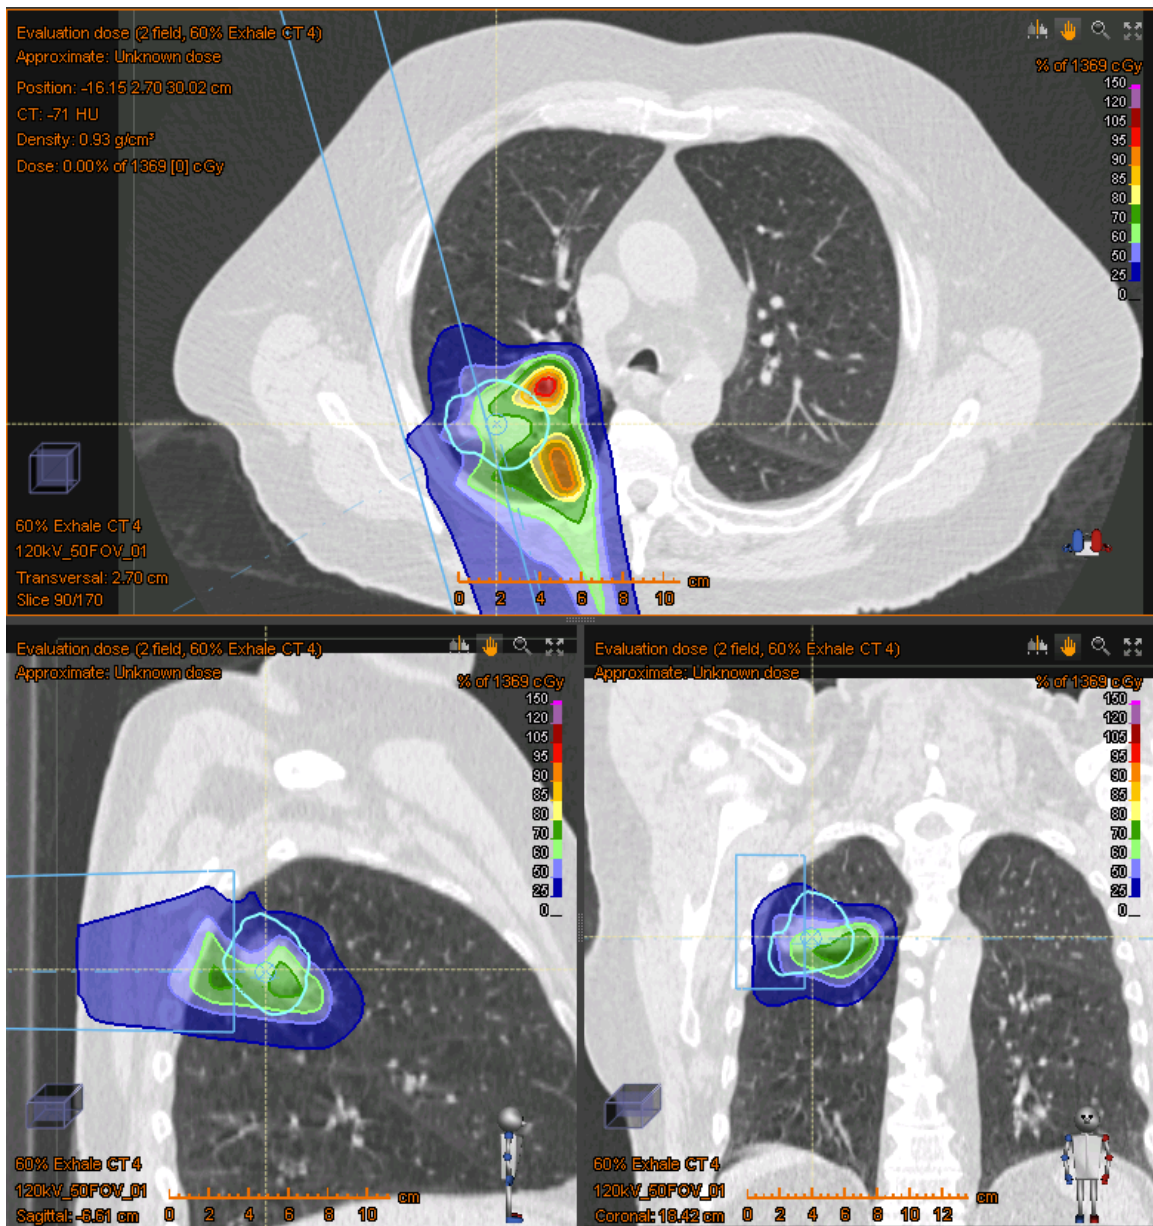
Field 1&2 – Dose delivered to 60% exhale CT phase
